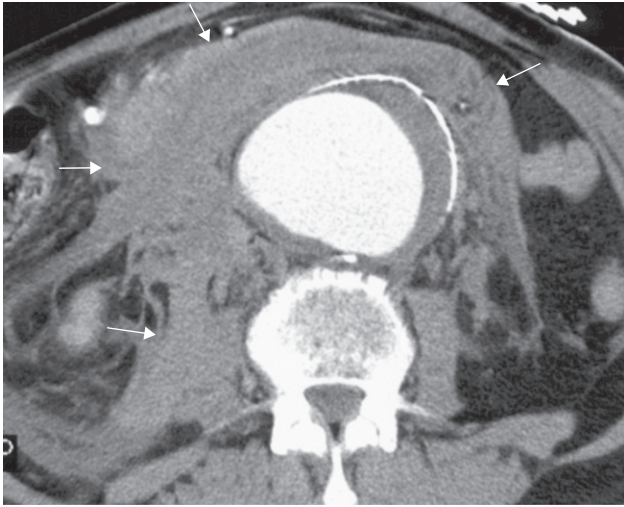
CT scan of a leaking abdominal aortic aneurysm showing the aneurysm and the haemorrhage in the adjacent retroperitoneum (arrows).
